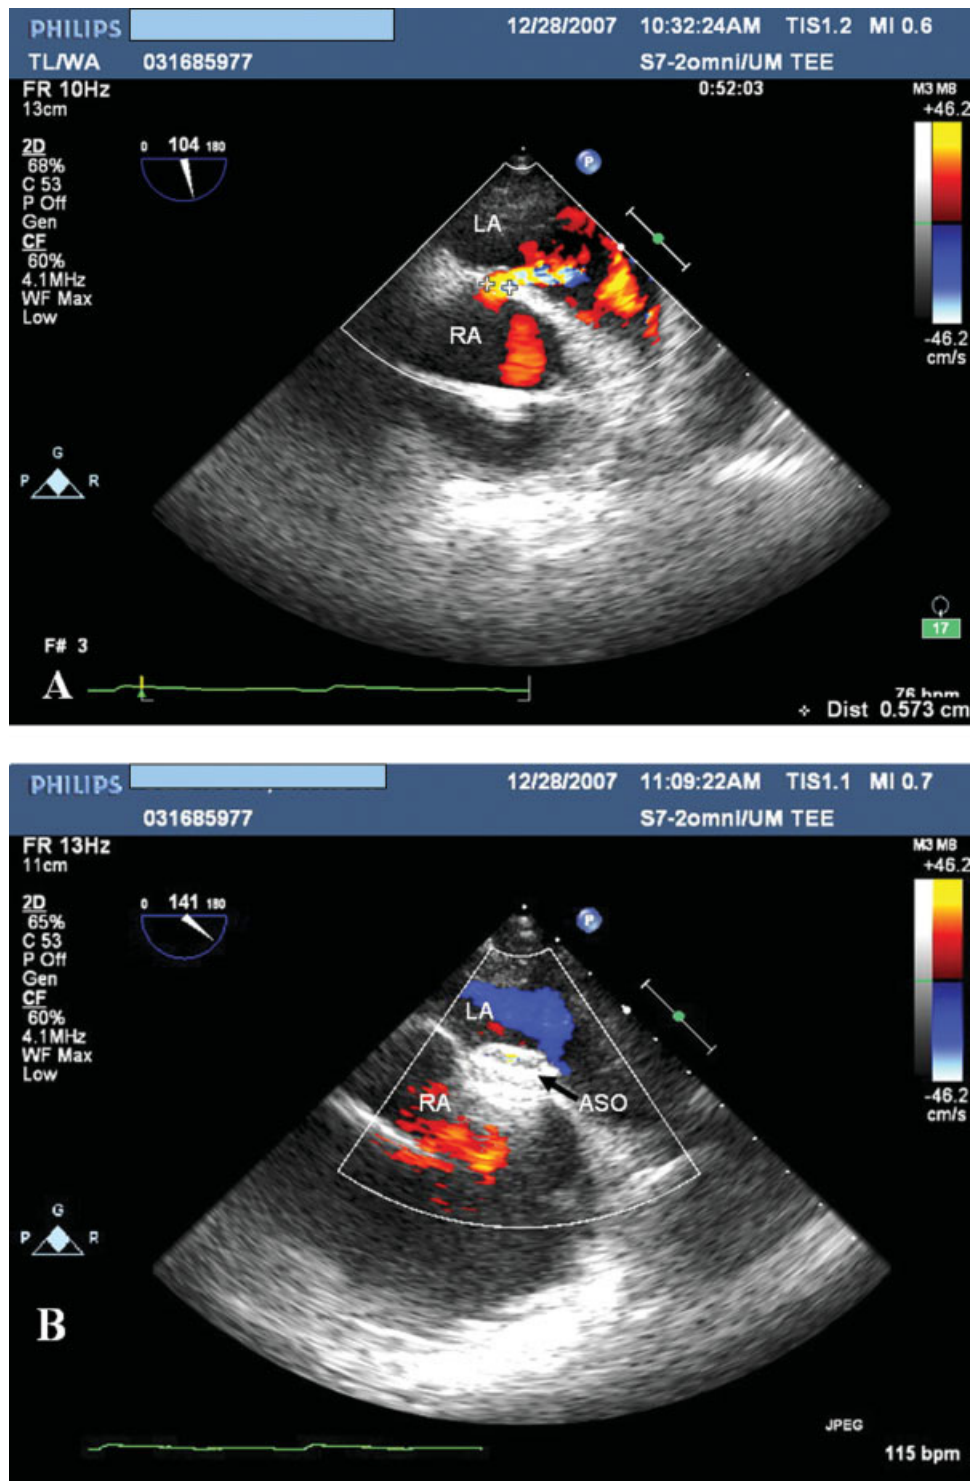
A: ASD with color flow Doppler demonstrating right to left shunting. B: Following deployment of the Amplatzer septal occluder device, no residual shunt is seen by TEE. [Color figure can be viewed in the online issue, which is available at www.interscience.wiley.com.]
